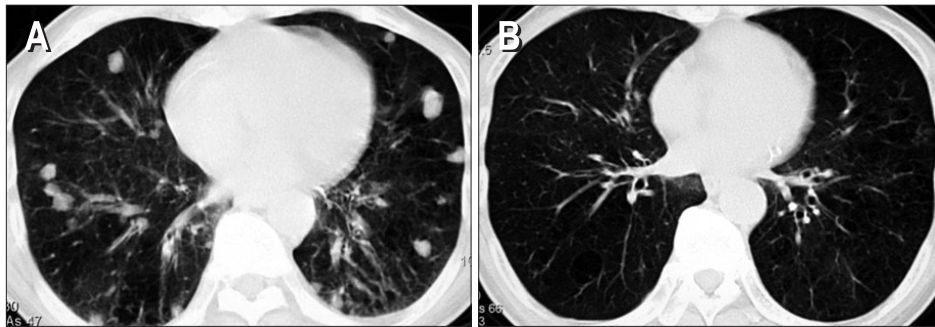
Computed tomography of the chest showed multiple nodules in the bilateral lungs, ranging up to 15 mm in diameter (A). After 9 months, the multiple nodules in the bilateral lungs had disappeared (B).
